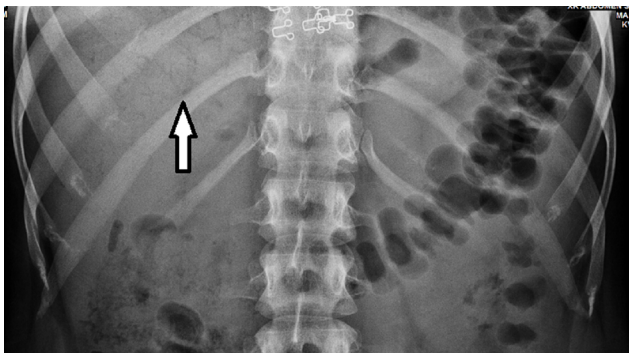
Abdominal X-ray showing linear branching shadows over liver shadow (arrow).
